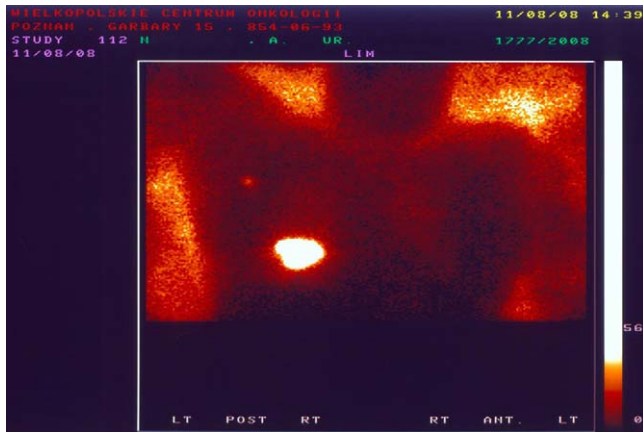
Lymphoscintigraphy (the big spot – the site of tracer injections, the small spot – the sentinel lymph node).
